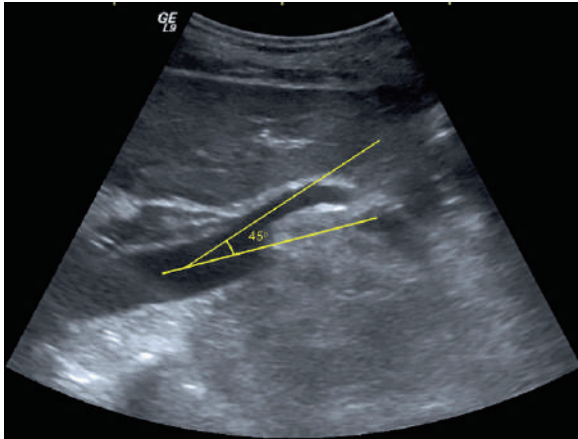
Sagittal ultrasound image shows the normal aorto-mesenteric angle
